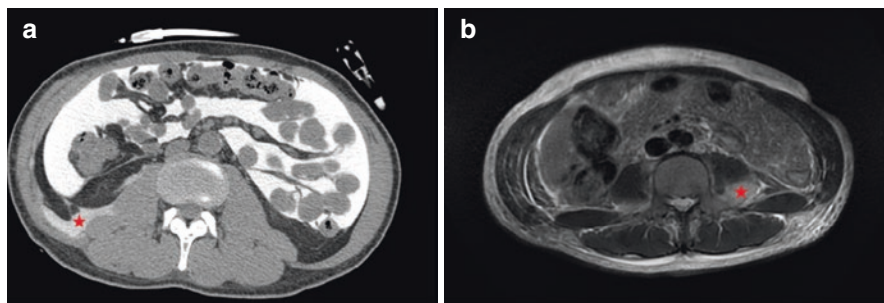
Computerized tomography with dye in the installed dialysate (Panel A) and magnetic resonance imaging (Panel B) demonstrating retroperitoneal leaks (star) in two individual cases
